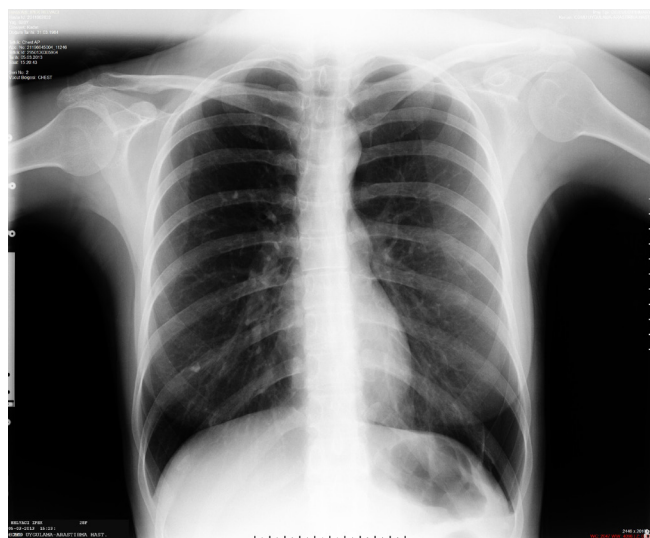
Postero-anterior chest x-ray of the patient in emergency service
